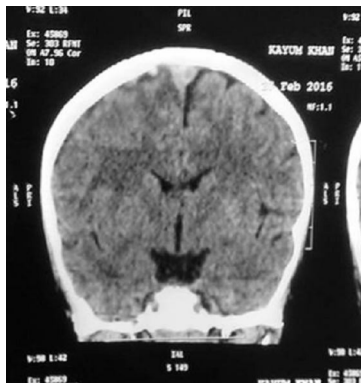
CT scan brain (coronal section) showing thin subdural hematoma over right high parietal convexity with underlying edema of the brain tissue
